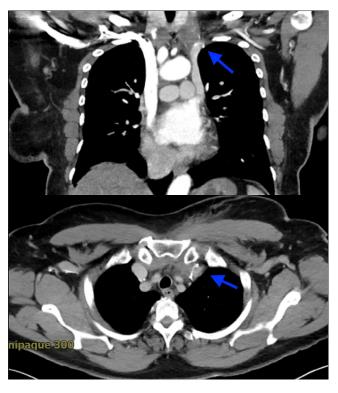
Computed tomography (CT) chest with intravenous contrast with 3-mm helical axial imaging and coronal reformation displaying rudimentary left superior vena cava (SVC) with retained guidewire at the left brachiobascilic junction.
